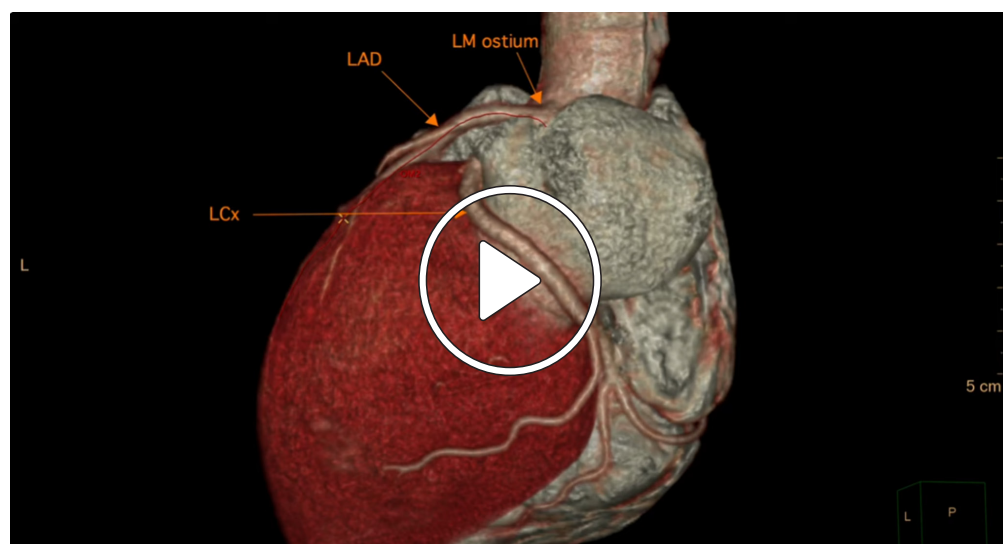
Coronary computed tomography angiography-subtracted VRT reconstruction image shows origin of right coronary artery (RCA) from left circumflex artery with absence of RCA ostium. VRT: volume rendering technique; LCx: left circumflex artery; LAD: left anterior descending artery
